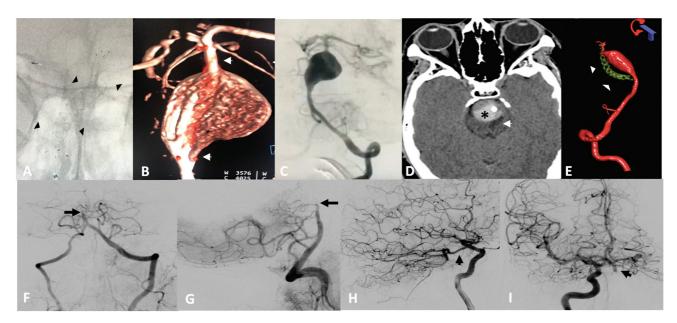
(A) Angiography showing flow diverter (FD) deployment in the basilar artery (black arrowheads) at procedure time; (B) three-dimensional (3D) reconstruction angiography showing the flow diverter device (FDD) into the basilar artery lumen surrounded by the giant aneurysm at procedure time (white thin arrows); (C) two-dimensional angiography showing flow from the left vertebral artery to distal basilar artery immediately after FD deployment; (D) At 6 months follow-up, brain computed tomography scan showing stasis inside the aneurysm and FDD artifact (black asterisk), as well as an ischemic stroke sequalae at left base pons (white thin arrow); (E) At 6 months follow-up, 3D reconstruction angiography showing FDD displacement into the thrombosed aneurysm and diminished size of basilar artery aneurysm; (F and G) At 1-year follow-up, anteroposterior and lateral angiography demonstrated occlusion of the mid-basilar artery (black arrows); (H and I) lateral and anteroposterior angiography showing collateral flow through the right posterior communicant artery to both posterior cerebral artery, distal basilar, both superior cerebral artery, and branches (black arrows).
